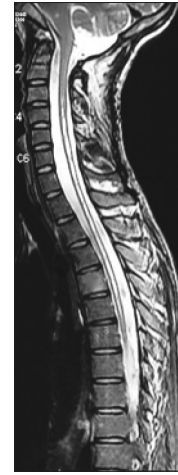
Post-operative magnetic resonance imaging sagittal T2-weighted image of the whole spine shows the significant but partial resolution of syrinx
